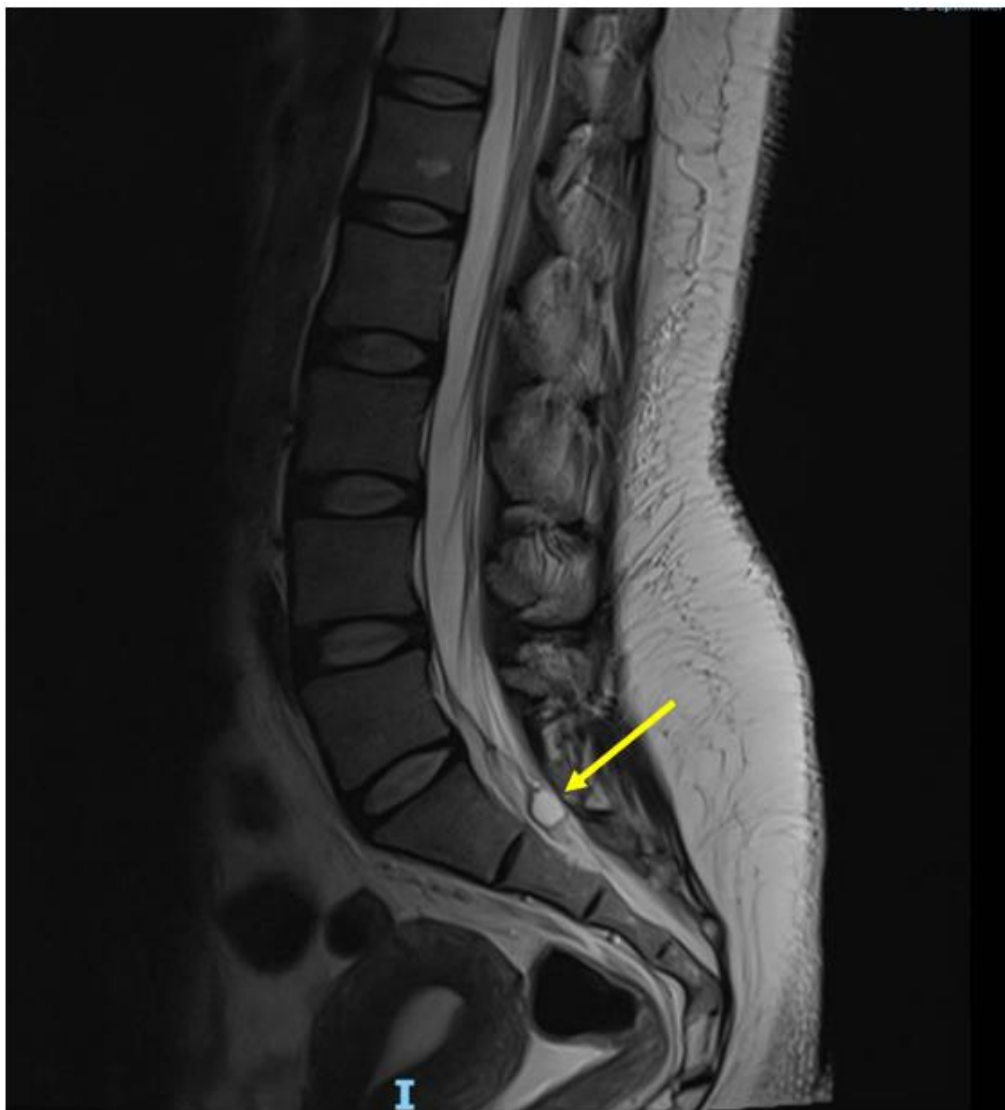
Sagittal T2-weighted MRI lumbosacral spine revealing Tarlov cyst (Yellow arrow) at the level of S1/S2.
